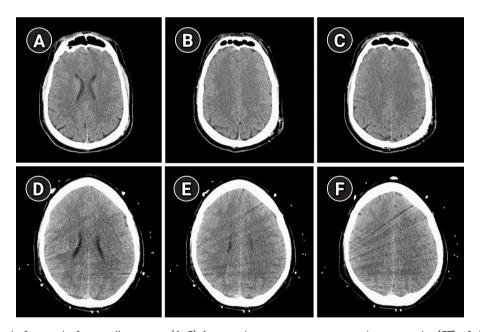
Head imaging before and after cardiac arrest. (A-C) A normal non-contrast computed tomography (CT) of the head obtained at admission with slices through the corona radiata and centrum semiovale. (D-F) Non-contrast CT of the head obtained 48 hours after cardiopulmonary arrest displaying interval development of sulcal effacement and subtle changes in grey-white matter differentiation at the level of the corona radiata and centrum semiovale.
